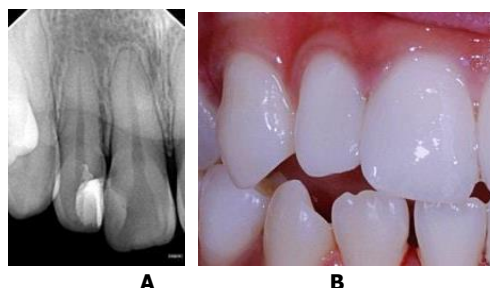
A. Radiograph of tooth #12 at two years post-treatment showing normal periapex. B. Clinical view of tooth #12 in two years.
